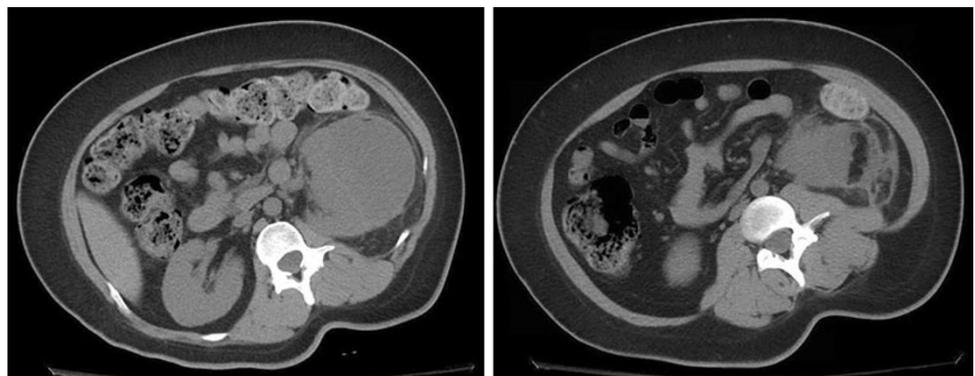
Image from a CT scan of the abdomen 3 months prior to presentation
